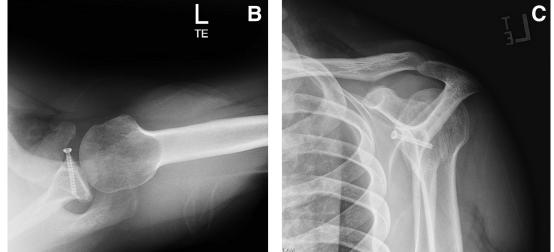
Postoperative (A) anteroposterior, (B) axillary, and (C) scapular-Y view radiographs showing anatomic reduction and stable fixation of the glenoid fracture.
